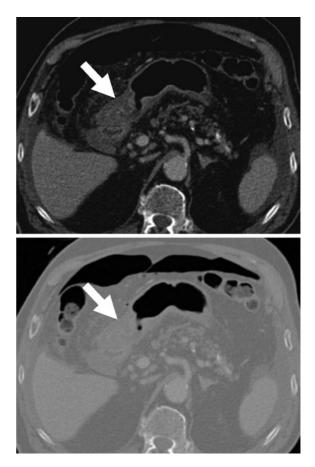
Perforated prepyloric ulcer secondary to nonsteroidal anti-inflammatory drugs in an 82-year-old male, contrastenhanced CT. Ulcer perforation site at the prepyloric gastric region with local wall thickening and fat stranding (*arrow*). Perihepatic and perisplenic ascites. The same image on the widewindow setting (*lower panel*) better depicts the extraluminal gas in the supramesocolic compartment
